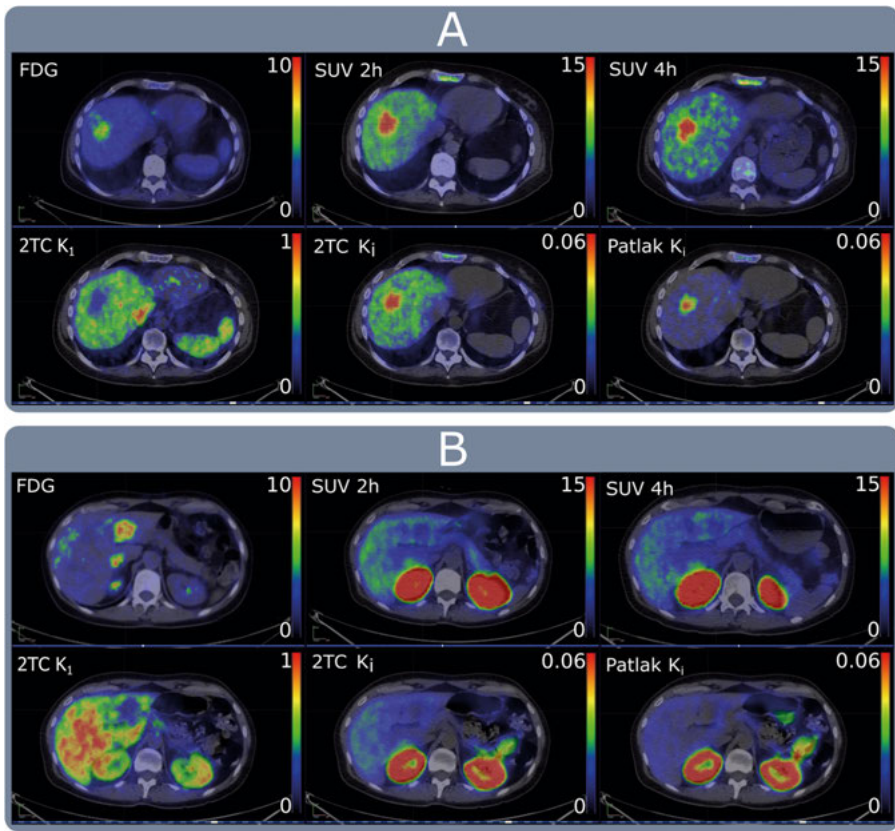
^{18}F -FDG PET/CT and ^{68}Ga -ABY-025 PET/CT images and parametric images derived from dynamic PET in A patient with HER2-positive liver metastasis B patient with HER2- negative liver metastasis. K_1 = delivery rate, K_i = net uptake rate, 2TC = irreversible two-tissue compartment
